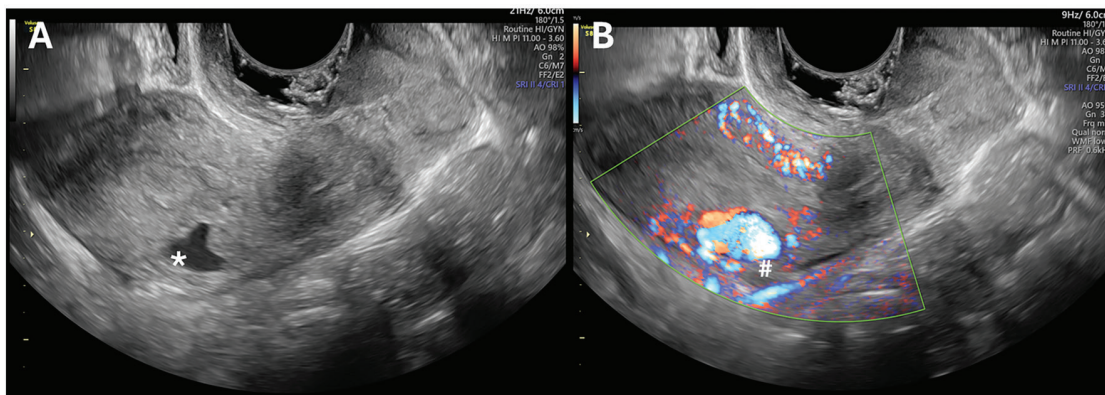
A) Grey scale ultrasound image of an anechoic area in the posterior myometrium (*), corresponding with an AV-shunt. (B) Power Doppler Image of this same image. Pulse Repetition Frequency 0.6 kHz. AV: Arteriovenous.
